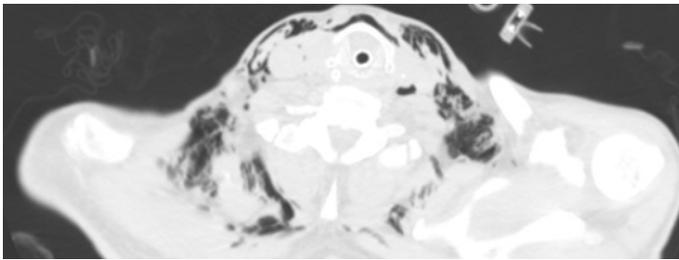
Subcutaneous emphysema and pneumomediastinum is seen in thorax CT
